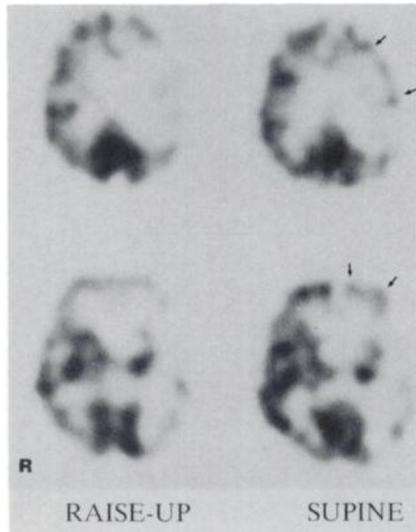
Patient 1 with 99% stenosis in the left internal carotid artery. Upright ^{99m}Tc-HMPAO brain SPECT shows decreased activity in the left fronto-parietal area. Subsequent supine ^{99m}Tc-HMPAO brain SPECT shows filling in the left fronto-parietal area (↑). The blood pressure drop during the upright test was 10 mmHg. (R = right, Raise-up = upright ^{99m}Tc-HMPAO brain SPECT, Supine = Supine ^{99m}Tc-HMPAO brain SPECT.)
